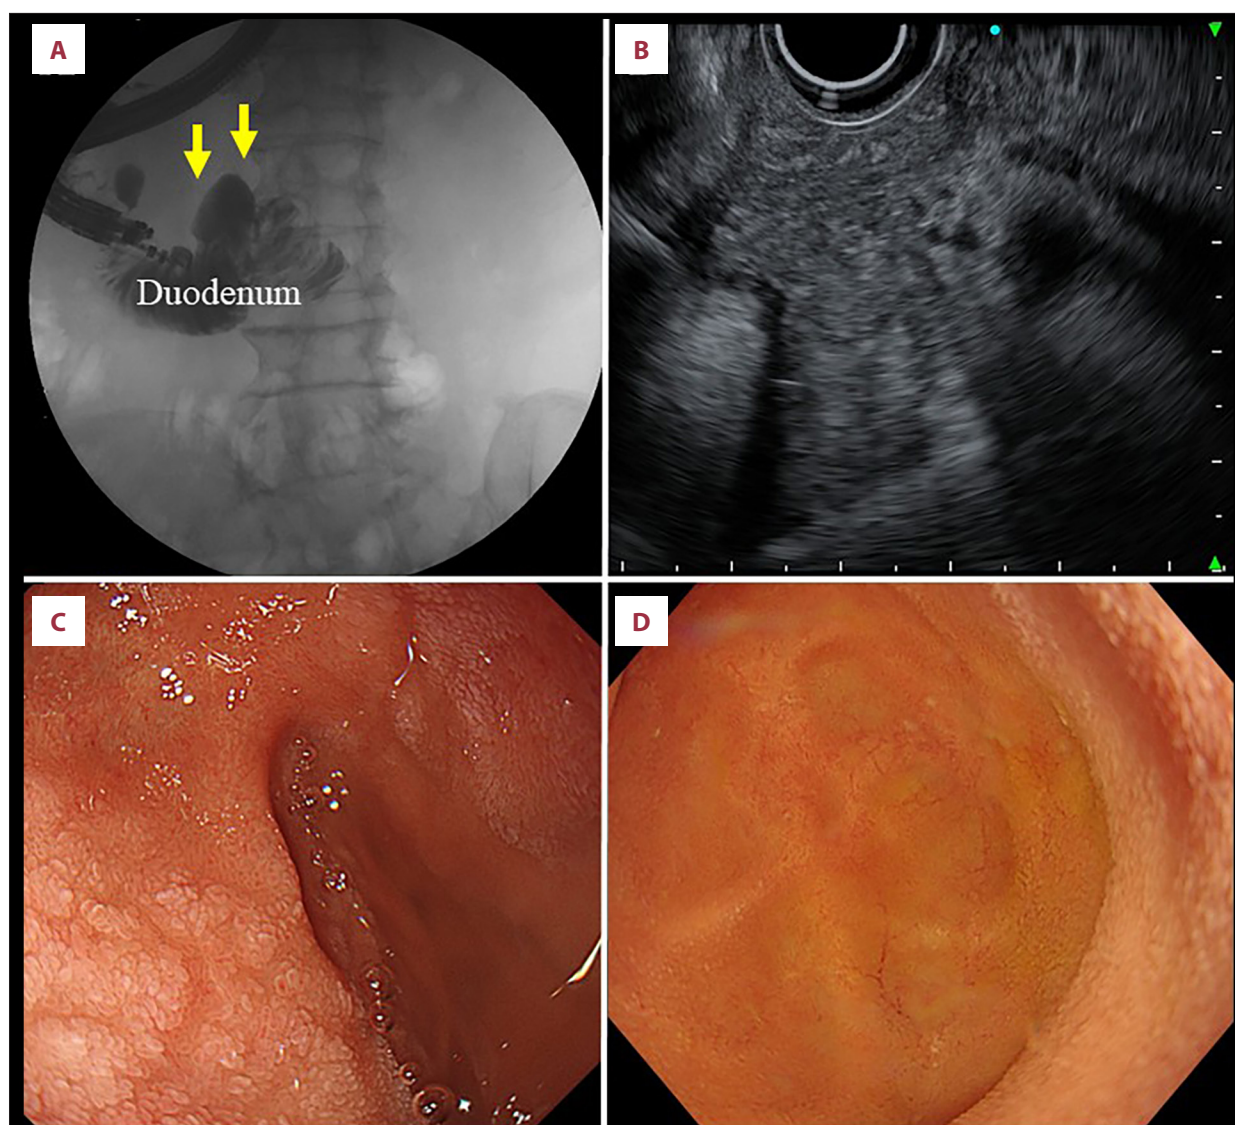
Findings of endoscopic examination accompanied by duodenography and ultrasound after surgery. Hypotonic duodenography did not reveal any filling defect within the duodenal diverticulum (yellow arrows) (A). Endoscopic ultrasonography confirmed the absence of any remnant fragment within the pancreatic parenchyma of the uncus (B). Endoscopic examination did not detect any remnant fragment within the diverticular cavity (C, D).
